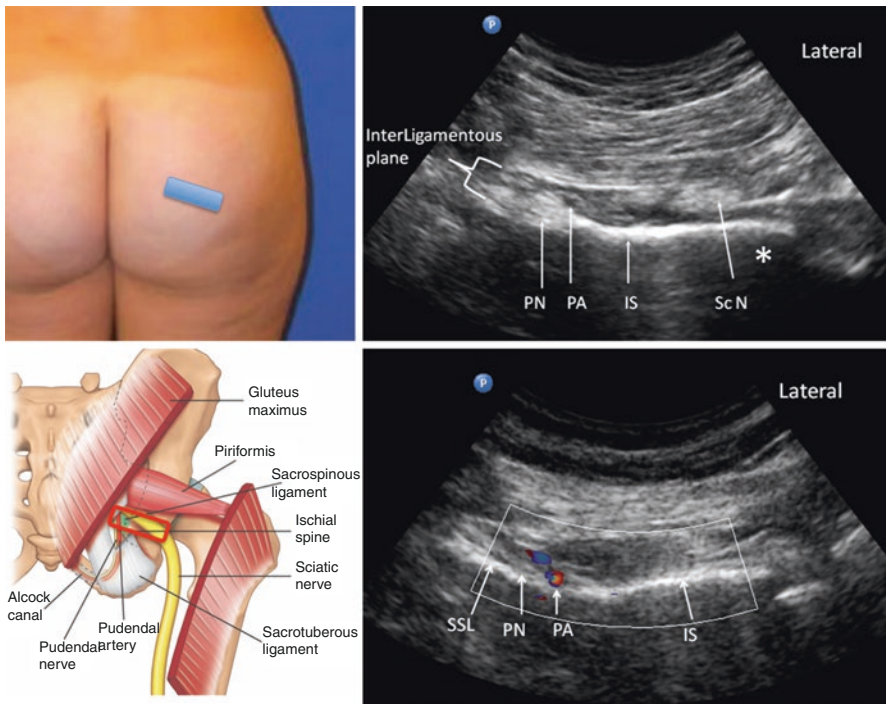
Position of the ultrasound probe at the ischial spine (IS) and the pertinent anatomy and sonoanatomy. SCN, sciatic nerve; PA and PN, pudendal artery and pudendal nerve; SSL, sacrospinous ligament; *, anechoic shadow cast by the ischium. (Reprinted with permission from Philip Peng Educational Series)
